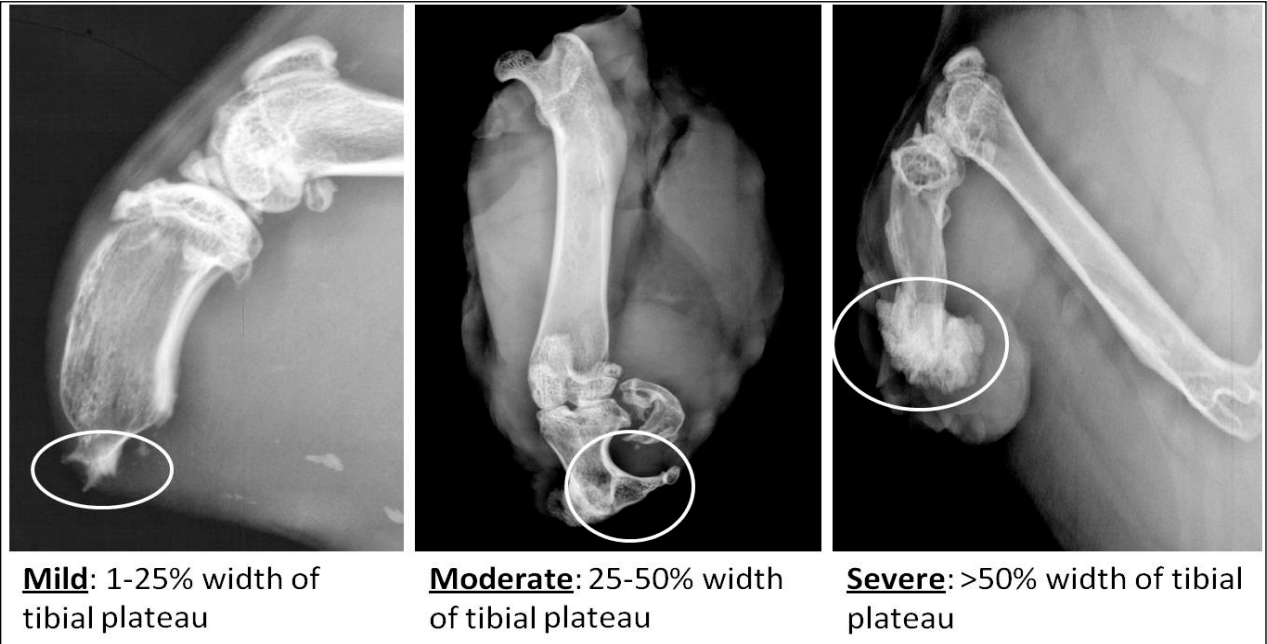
Radiographic key used for grading HO severity.
